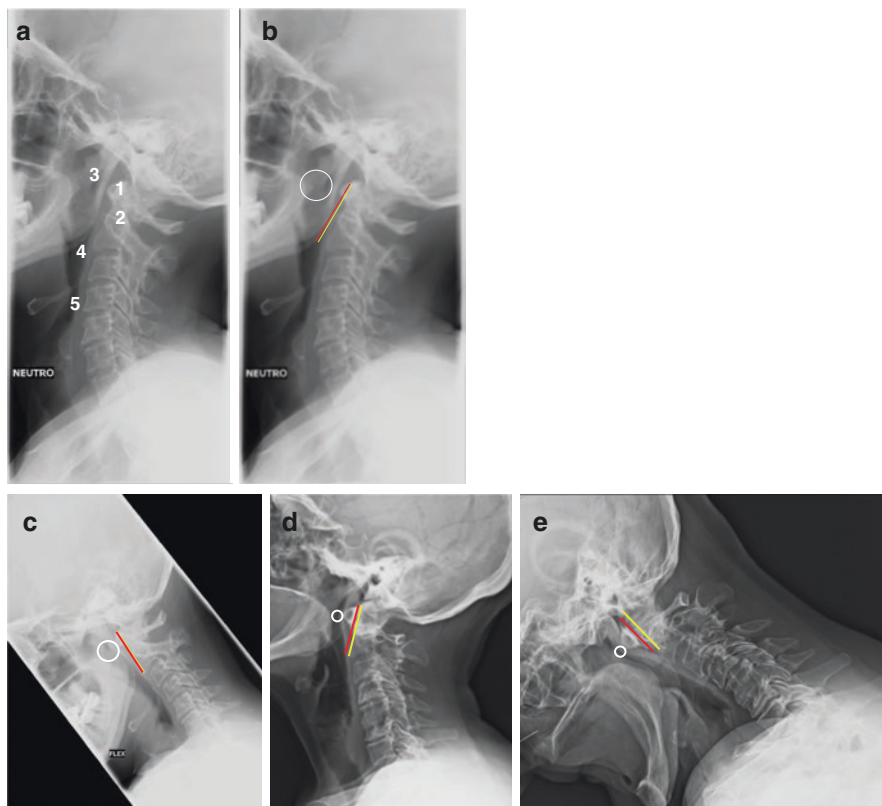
(a) Lateral X-ray of the normal cervical spine (neutral position). Some anatomical structures are indicated: C1 vertebra (1), C2 vertebra (2), nasopharynx (3), oropharynx (4) and laryngopharynx (5). (b and c). In a normal cervical spine, both in the neutral position and in flexion, the anterior arch of C1 (red line) and the odontoid process of C2 (yellow line) are united and the nasopharynx retains its caliber (white circle). (d and e). When dislocation between C1 and C2 occurs in rheumatoid arthritis, the separation of the first two vertebrae (separation of the red and yellow lines) is accentuated by flexion of the cervical spine and may be accompanied by a decrease in the caliber of the nasopharynx (white circle)
